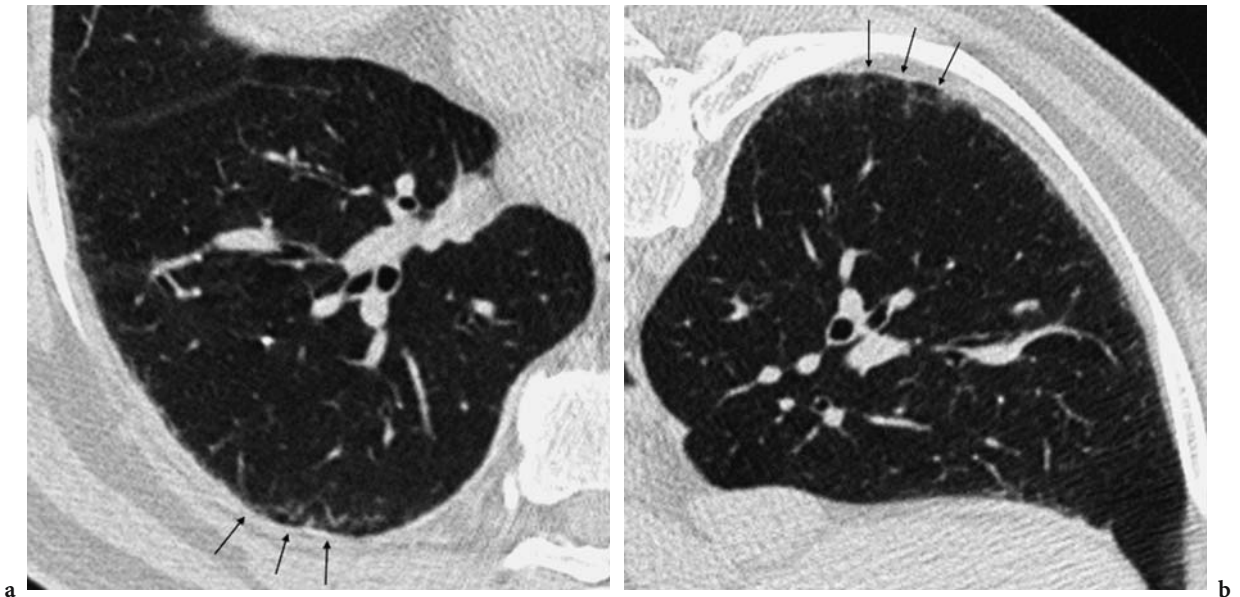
Thin-section computed tomography images obtained supine a and prone b in a 73-year-old worker exposed to asbestos. A fine reticular pattern (arrows) and increased ground glass attenuation are seen on the supine image, predominantly in the dependent areas. These features persist on the prone images and are in keeping with early asbestosis
